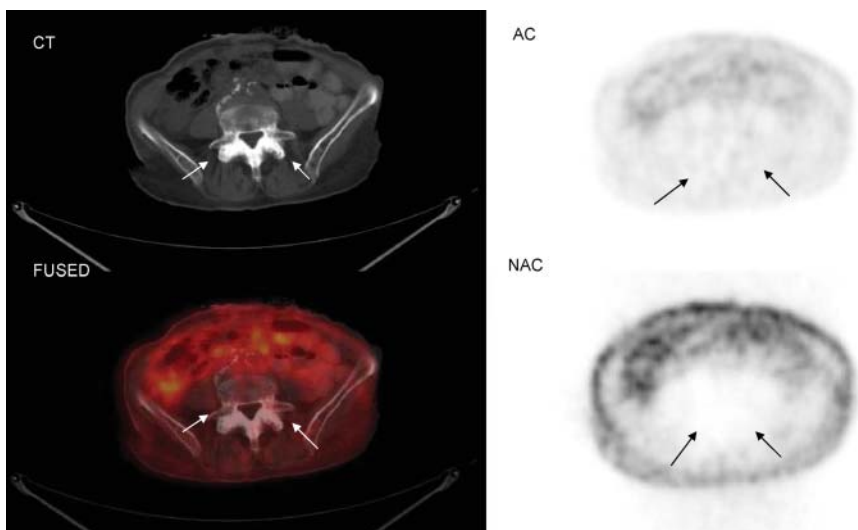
$^{18}\text{F}$ -FDG PET/CT images of cervical spine show abnormal  $^{18}\text{F}$ -FDG uptake in region of disk and facet joint disease seen on CT (arrows). AC = attenuation-corrected PET image; FUSED = fused CT and PET images; NAC = nonattenuation-corrected PET image.
